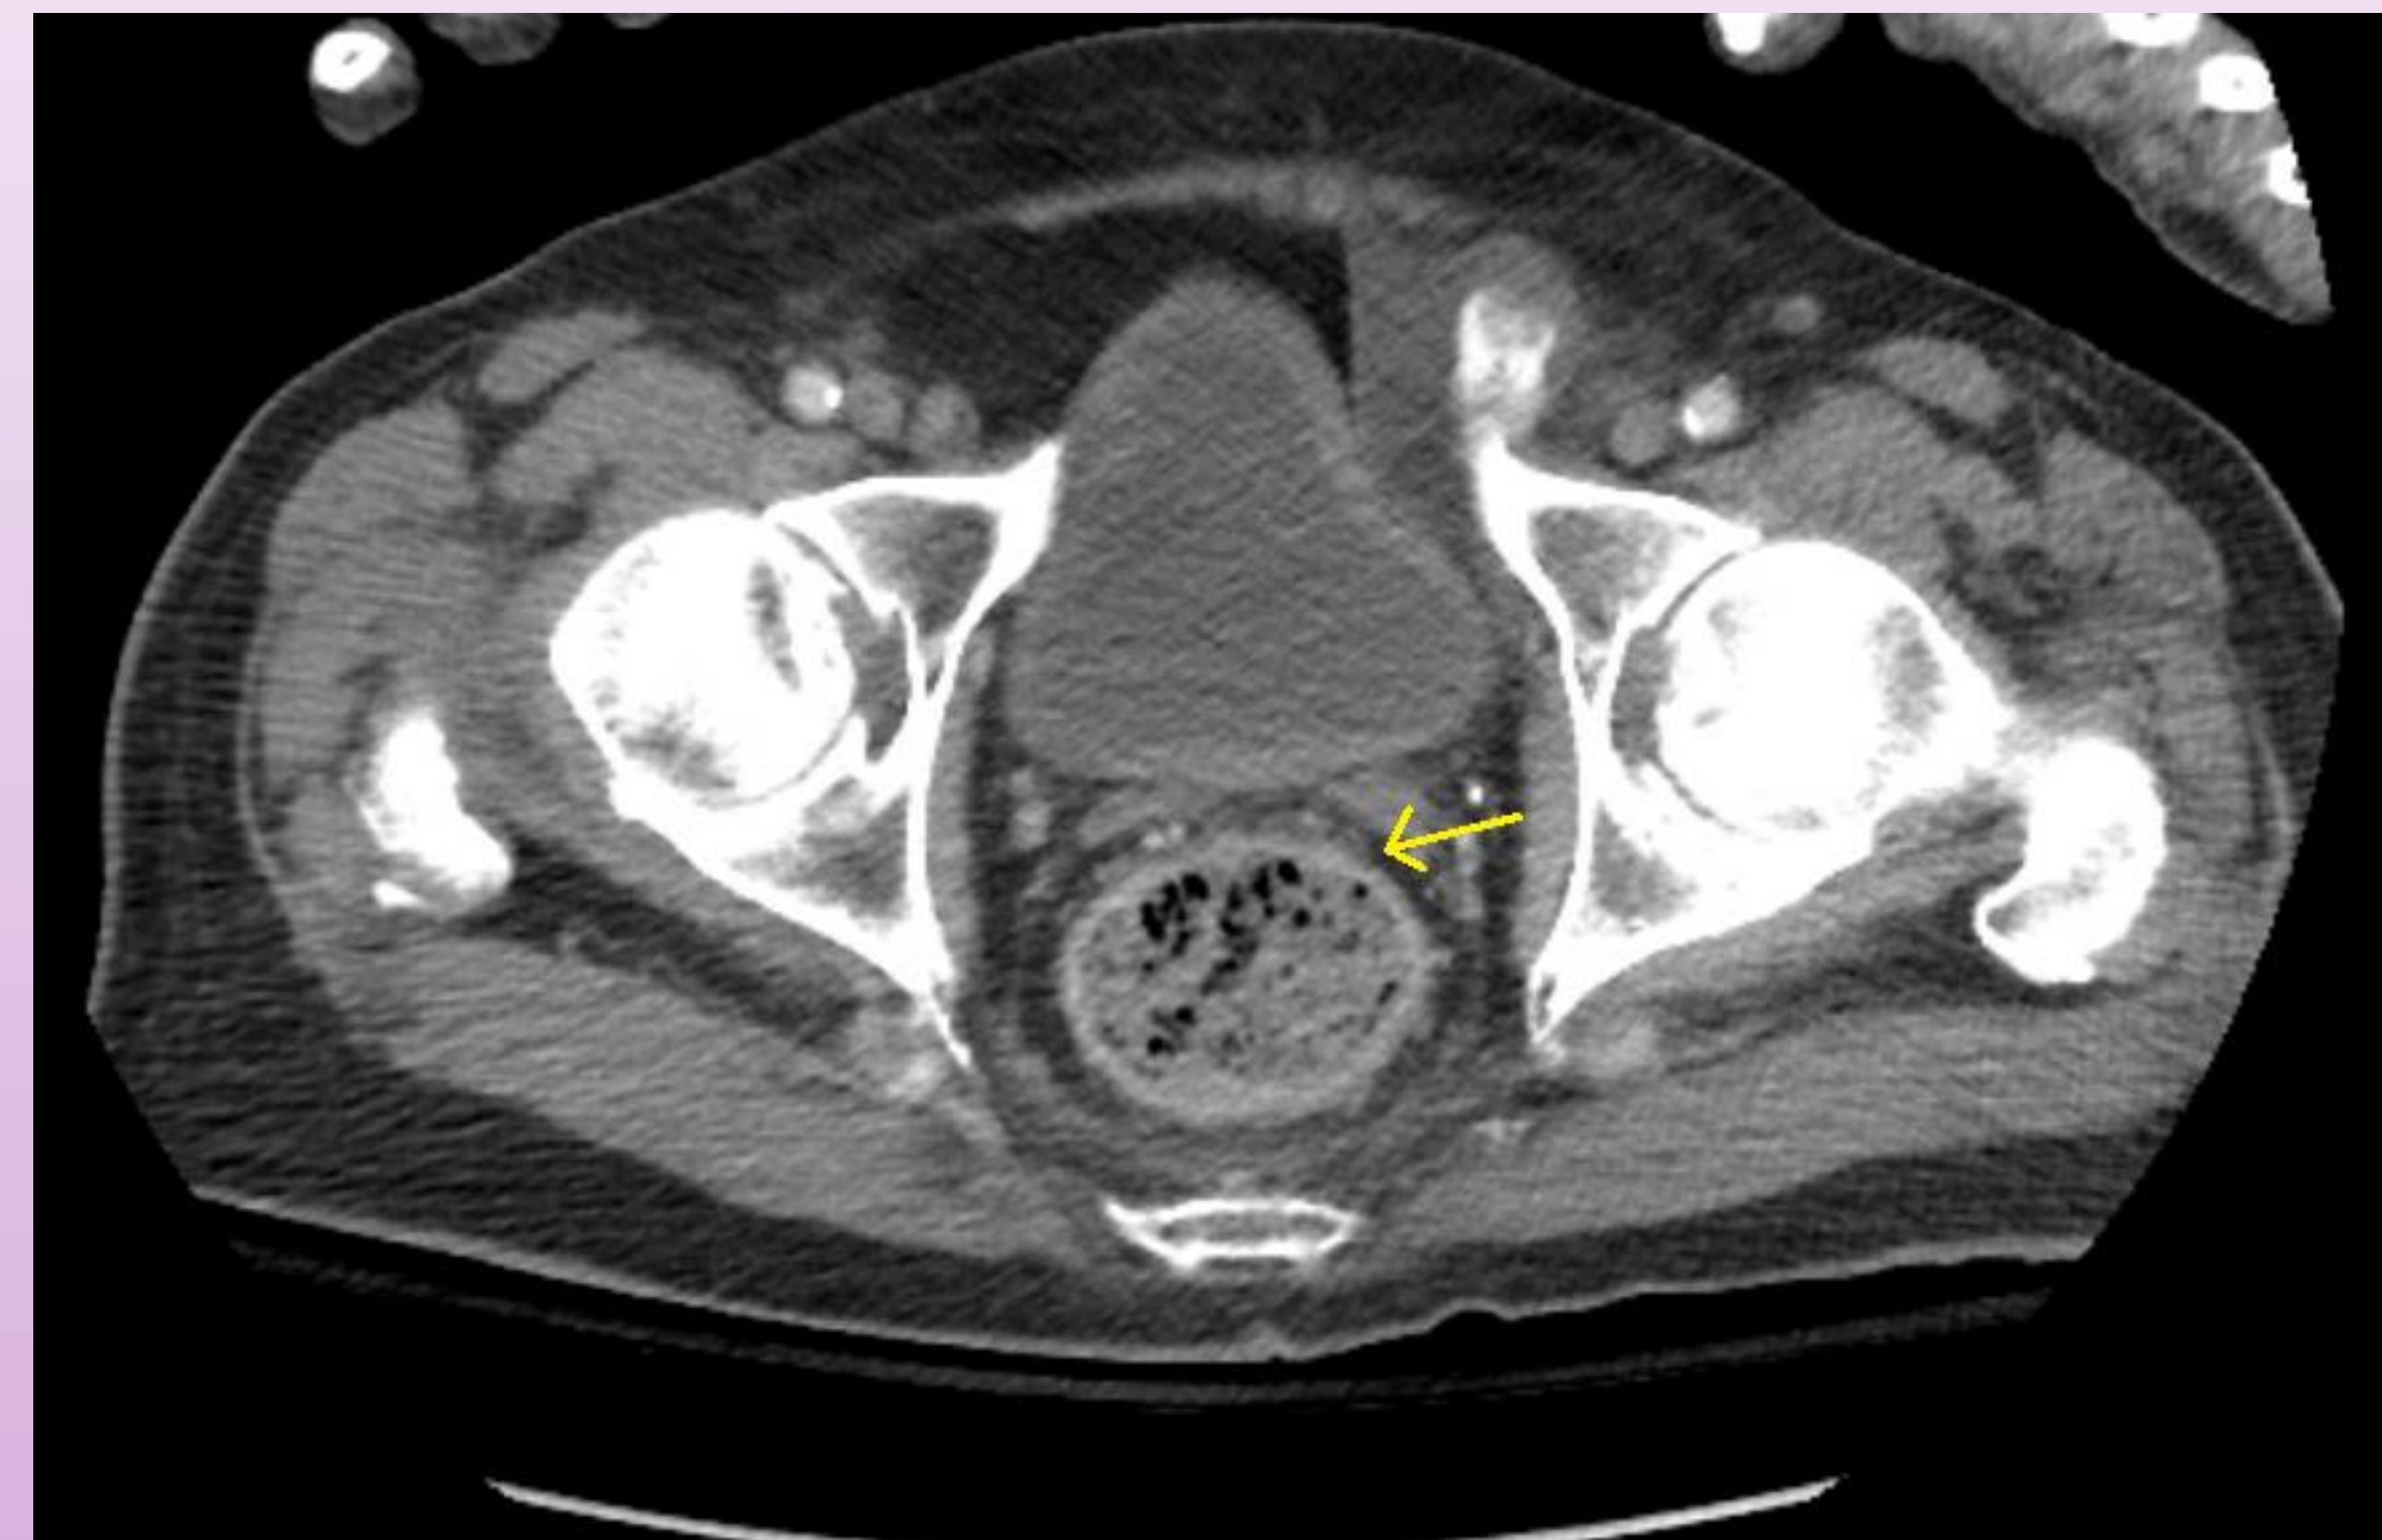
CT abdomen/pelvis of patient in the ER.
